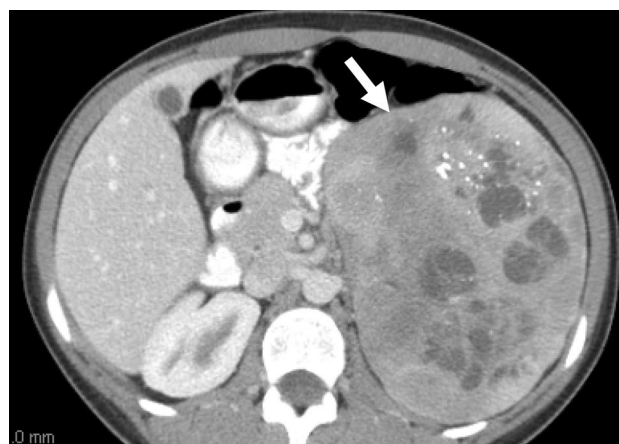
A 23-year-old female patient with a palpable left upper quadrant abdominal mass. Axial contrast-enhanced abdominal CT shows a large left adrenal mass (white arrow) with areas of necrosis and coarse calcifications. The mass was biochemically inactive. Based on imaging features, ACC was suspected. The mass was pathologically proven ganglioneuroma
